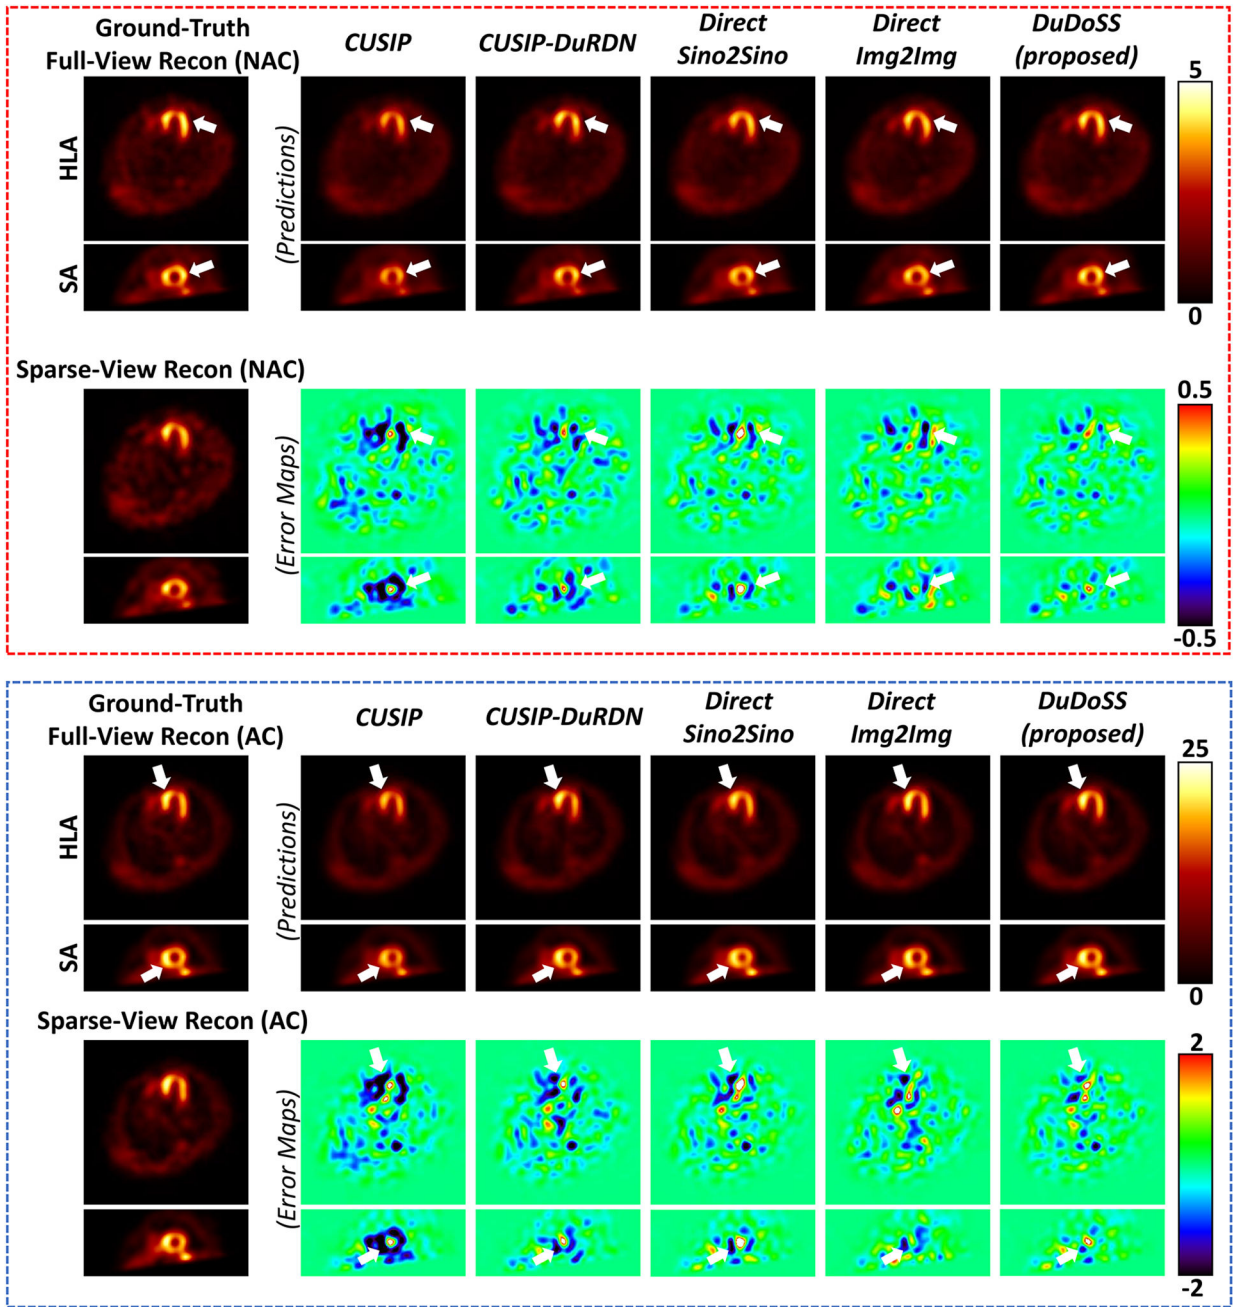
Sample NAC and AC SPECT images and corresponding error maps shown in the horizontal long axis (HLA) and the short axis (SA) views. The NAC SPECT images are shown in the top red dash box, and the AC SPECT images are shown in the bottom blue dash box. DuDoSS outputs the most consistent NAC and AC SPECT images with the ground-truth full-view SPECT images. Errors between the predicted and ground-truth SPECT images are denoted with white arrows.
